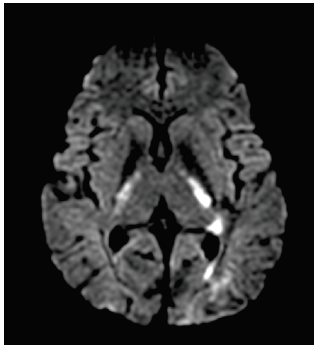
Diffusion restriction in left internal capsule in DWI
